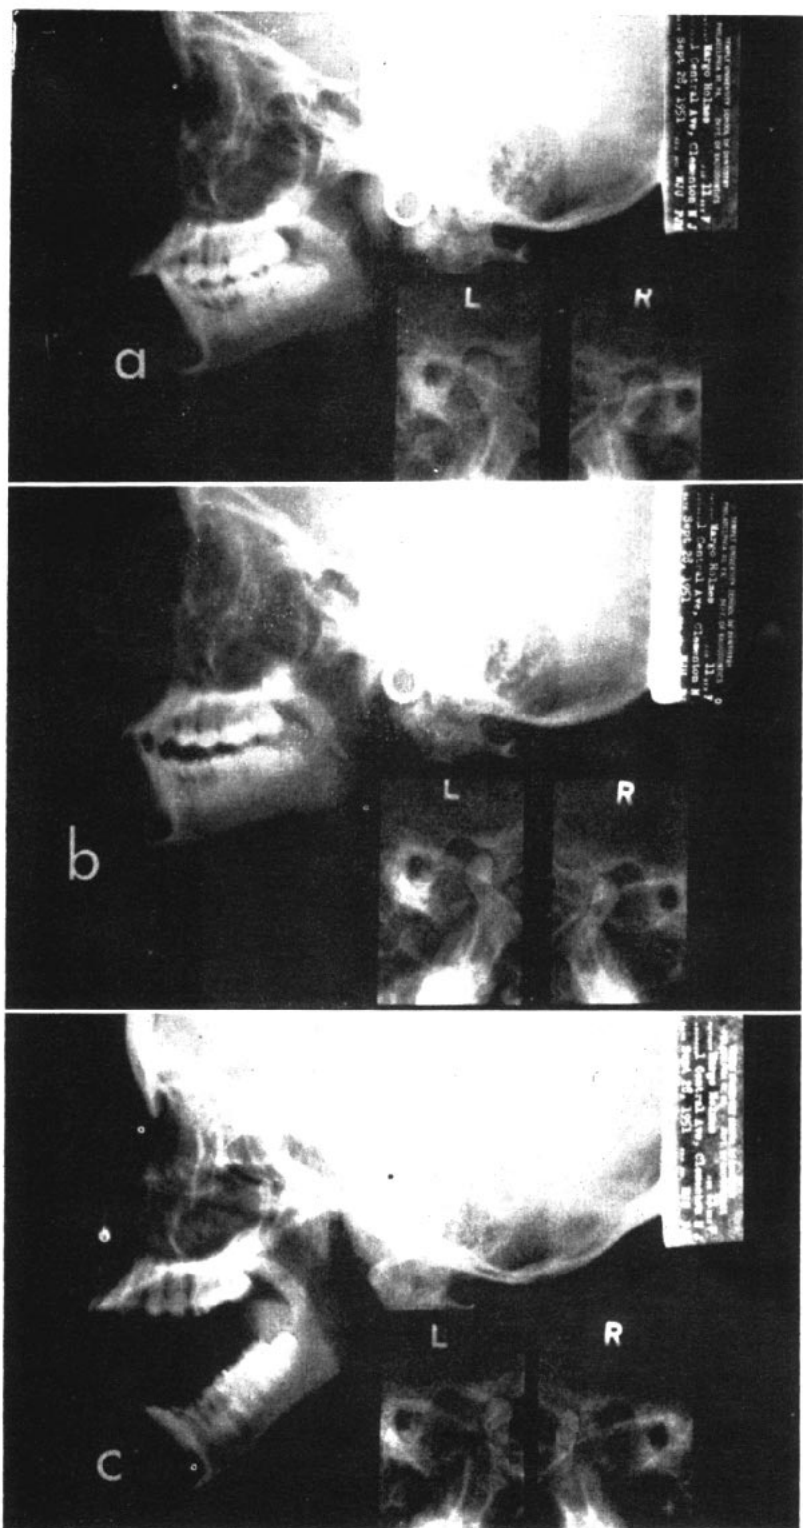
Lateral head and temporomandibular radiographs of Class II malocclusion. (a) centric (b) rest (c) opened.
